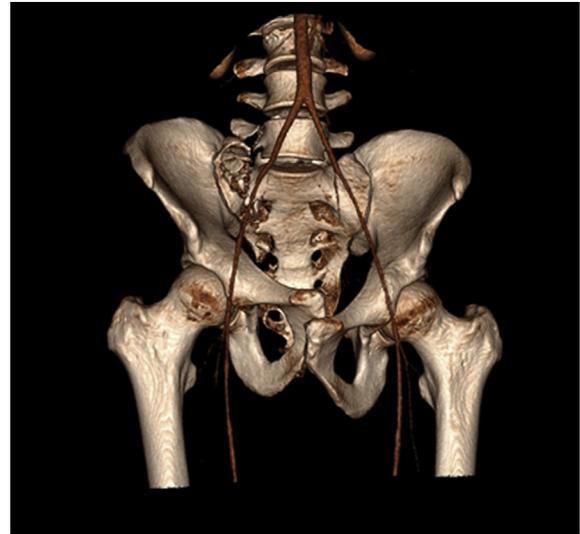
Axial CT of the pelvis in vertical shear injury: 3D reconstruction demonstrating vertical displacement of right hemipelvis.
